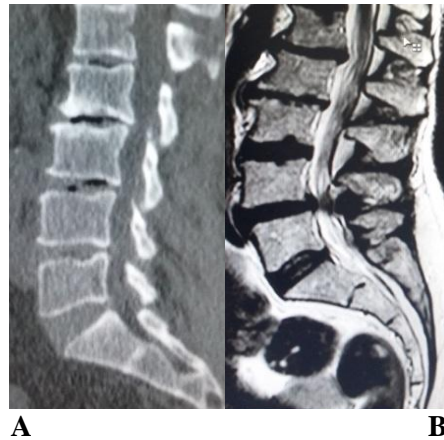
A: MRI T2 weighted scan and B lumbar disc vacuum
